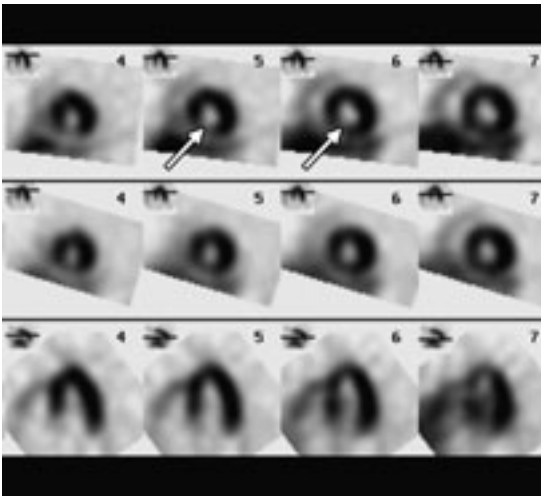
Myocardial scintigraphy. An apical perfusion defect (arrow).
